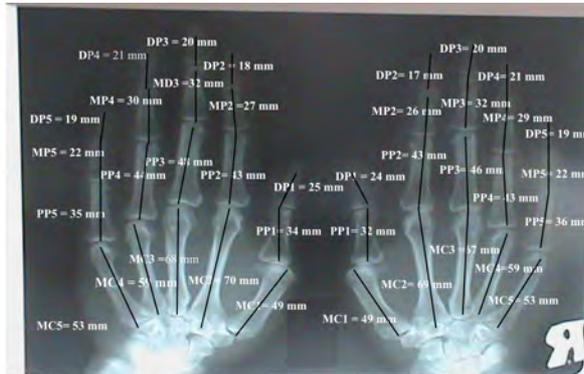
A Radiograph demonstrates the measurements of all metacarpals and phalanges of the right and the left hands (MC= metacarpal; PP= proximal phalanges; MP = middle phalanges and DP= distal phalanges).
